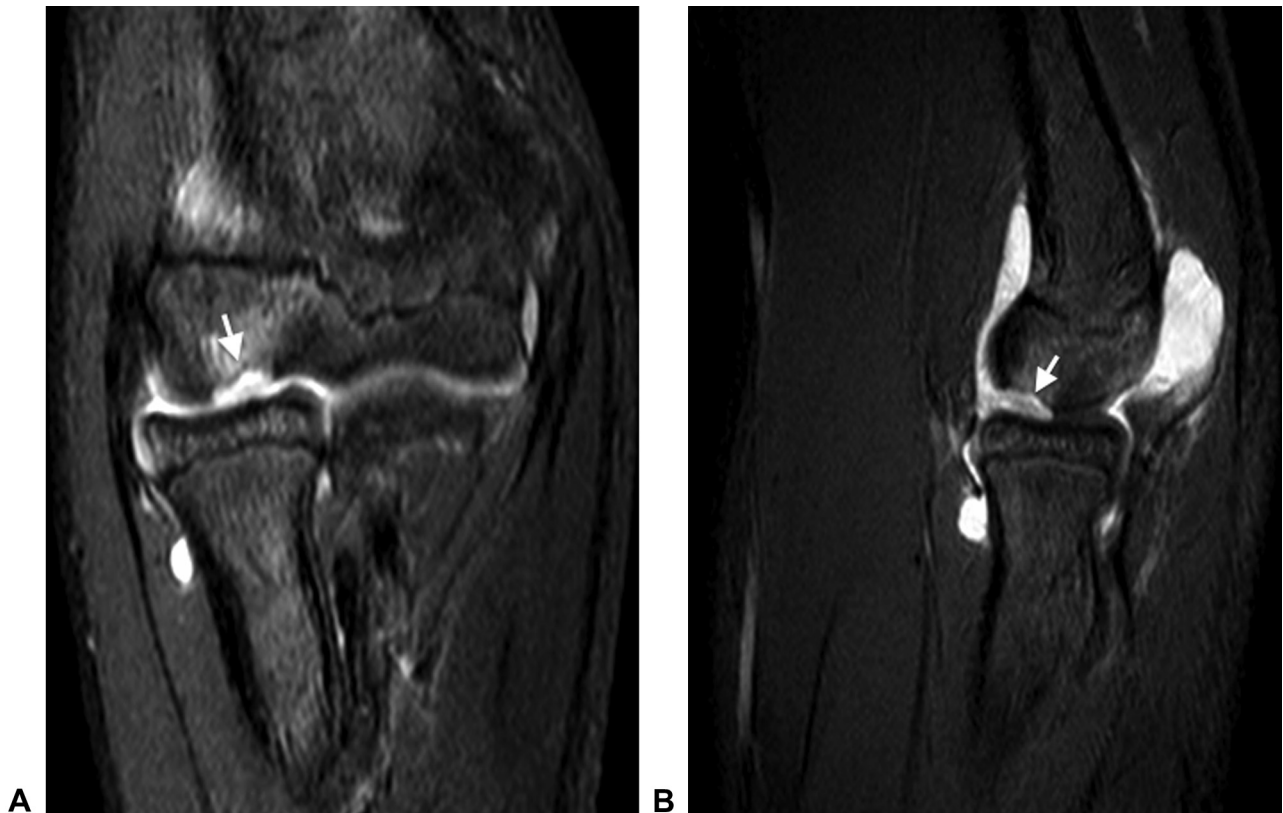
A Coronal and B sagittal magnetic resonance imaging of the same patient better defines the degree of bone and cartilage loss (white arrows). (Courtesy of Shriners Hospital for Children—Philadelphia.)
